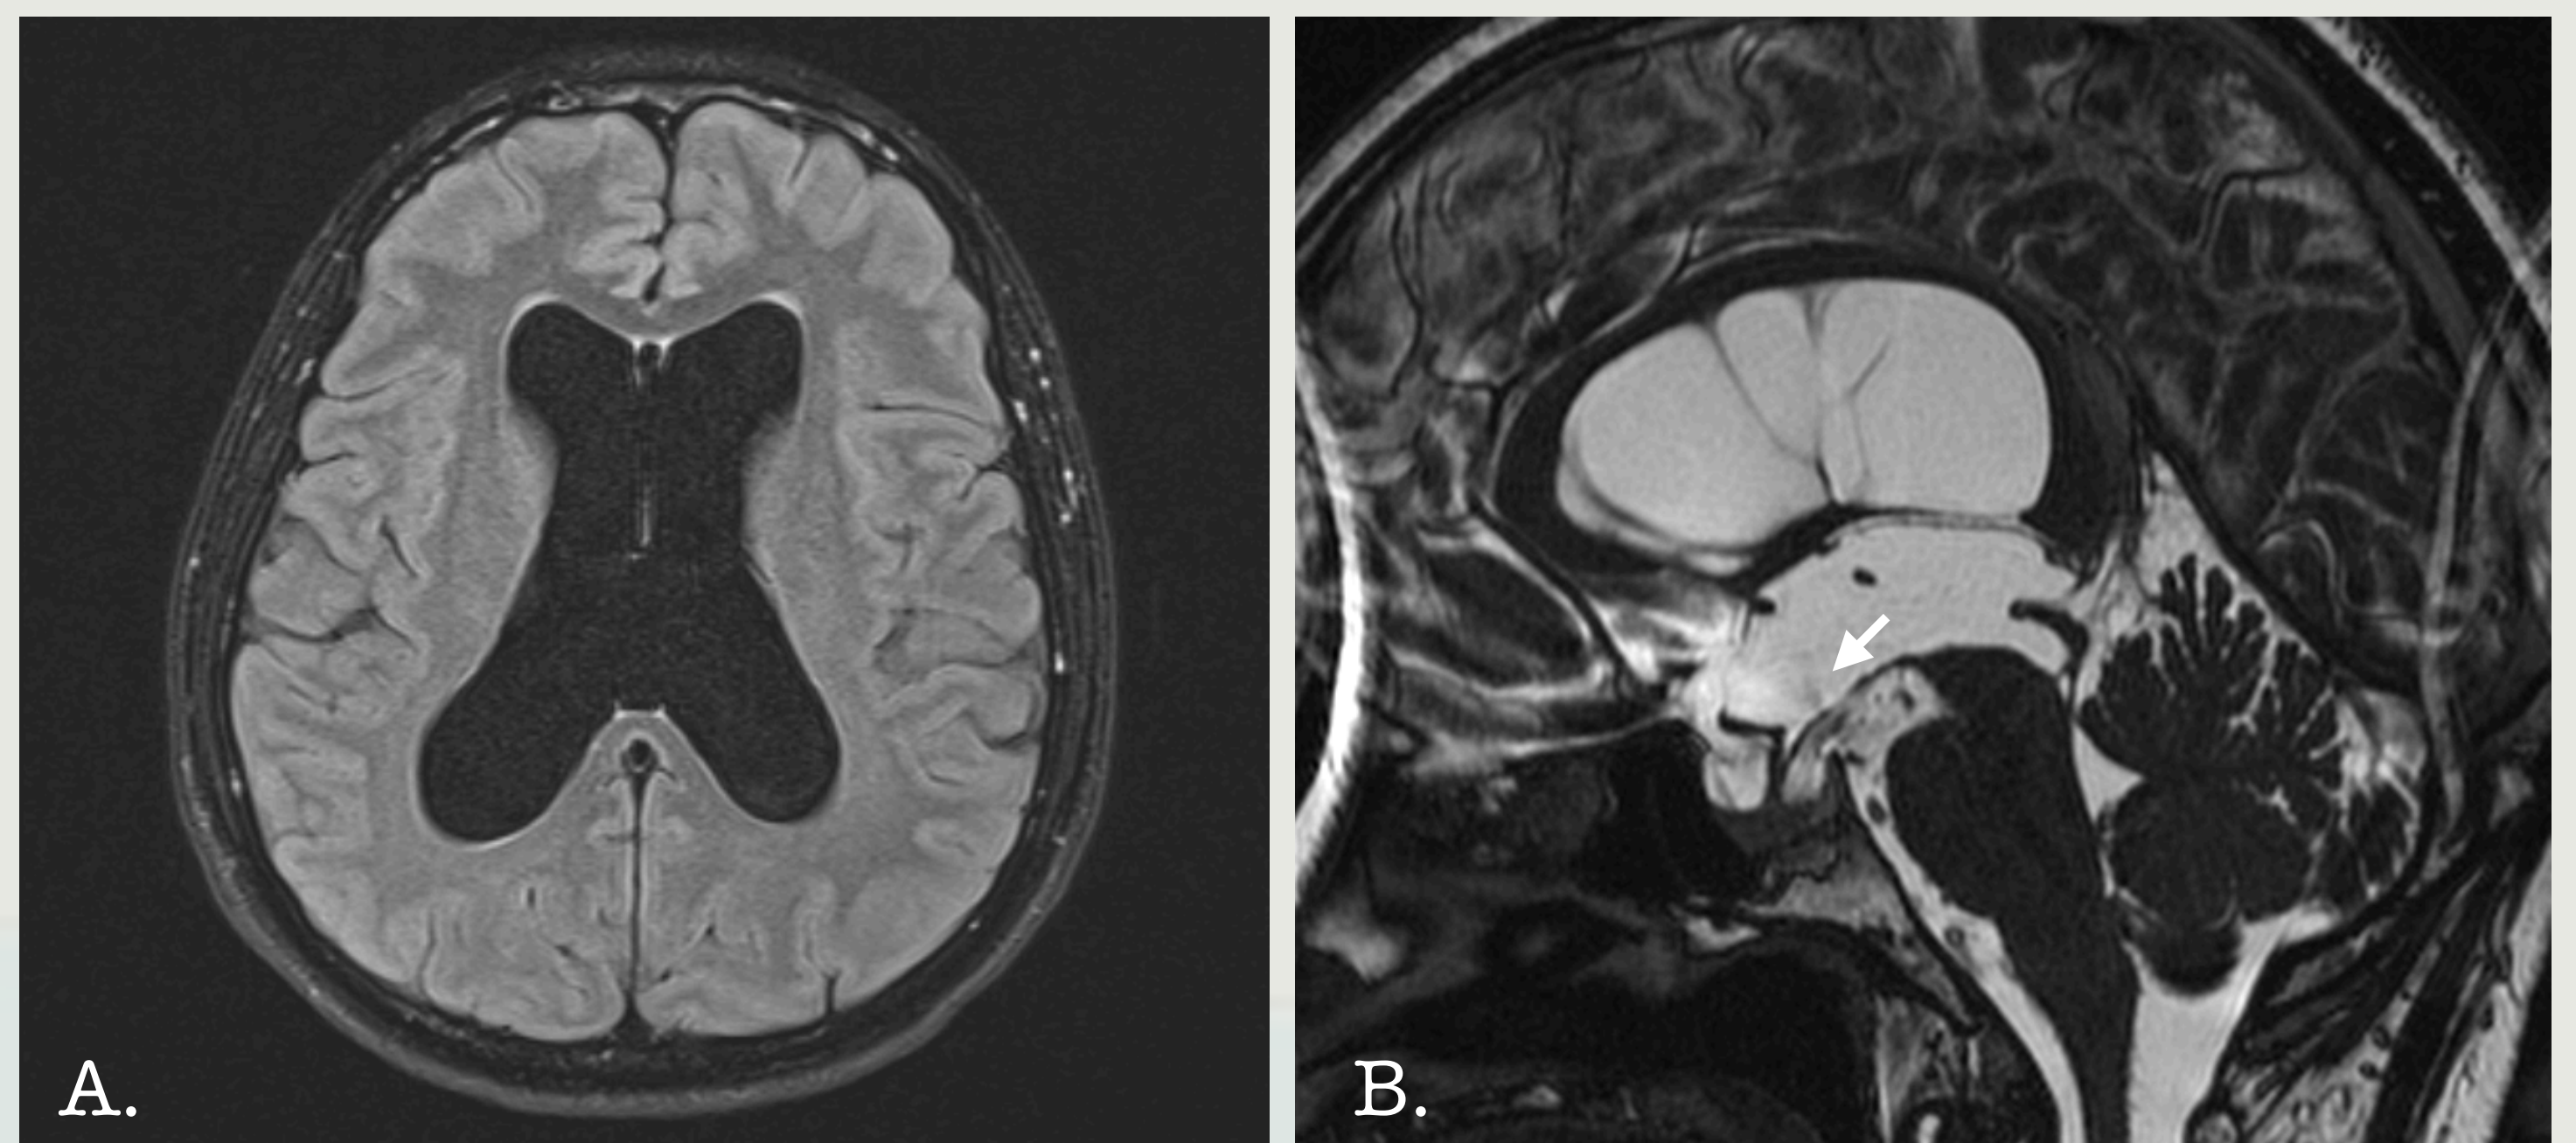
MRI T2 FLAIR-weighted sequence showing massive dilatation of the ventricles in aqueductal stenosis (A). After ventriculocisternostomy, MRI T2 CISS sequences images revealed CSF flow (flow void, see arrow) through the floor of the third ventricle between the tuber cinereum and the mammillary bodies, connecting ventricular system with prepontine cistern (B).
